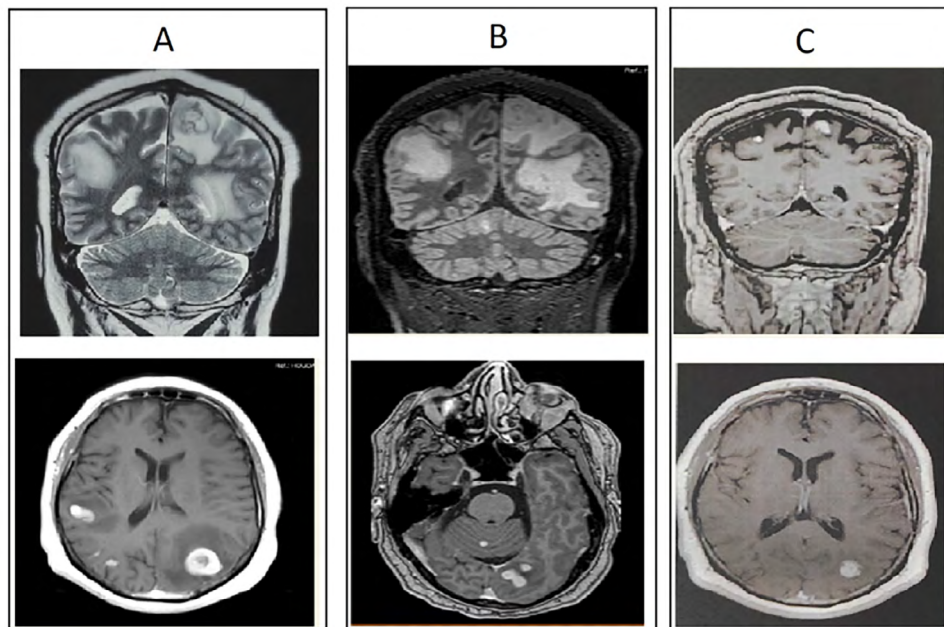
Evolution of the MRI abnormalities: A: At diagnosis of TB, B: After one month of treatment, C: After 6 months of treatment.
